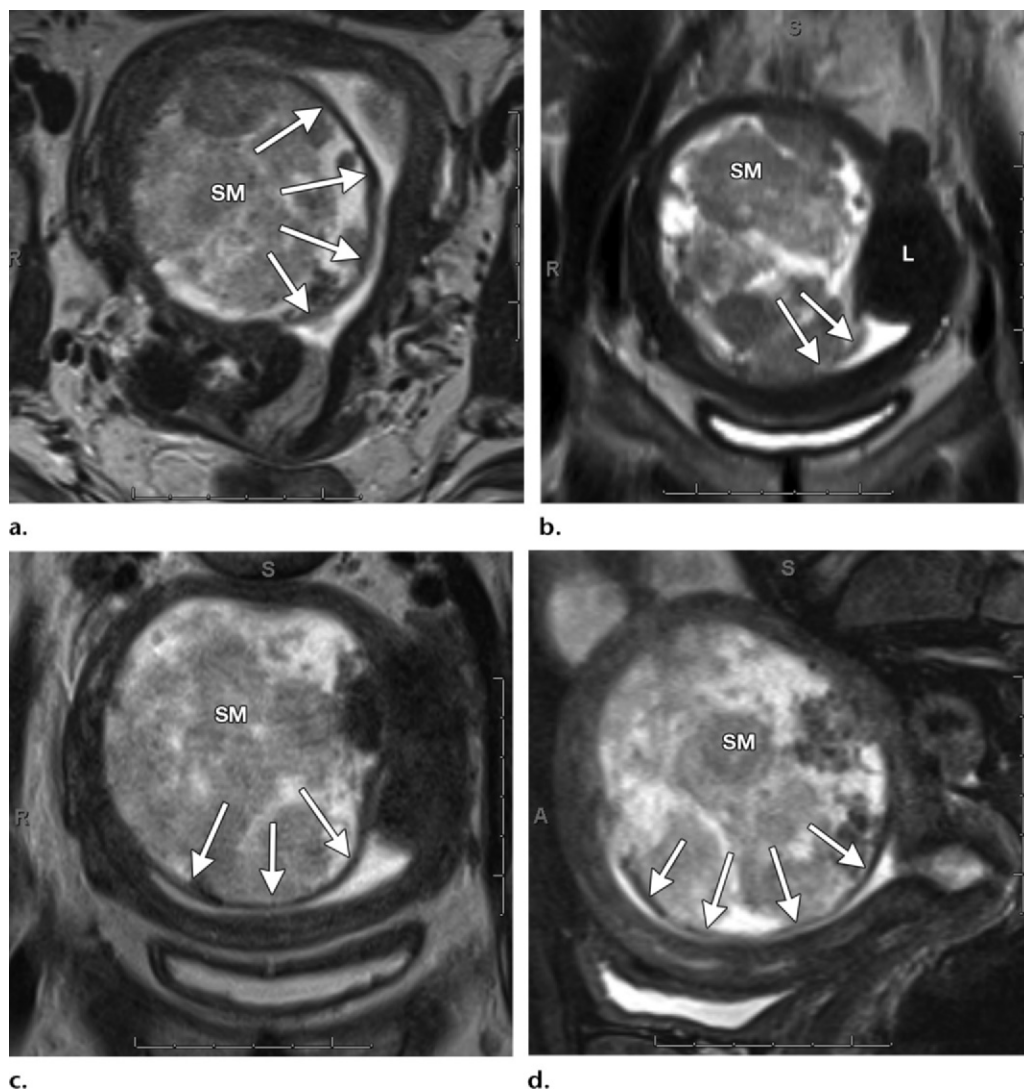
Degenerated submucosal leiomyoma in a 46-year-old woman. Axial (a), coronal (b), oblique coronal (c), and sagittal (d) T2-weighted images show a degenerated leiomyoma (SM) that is located below the mucosal surface and protrudes into the endometrial cavity (arrows). Also note the nondegenerated submucosal leiomyoma (L) in b.
